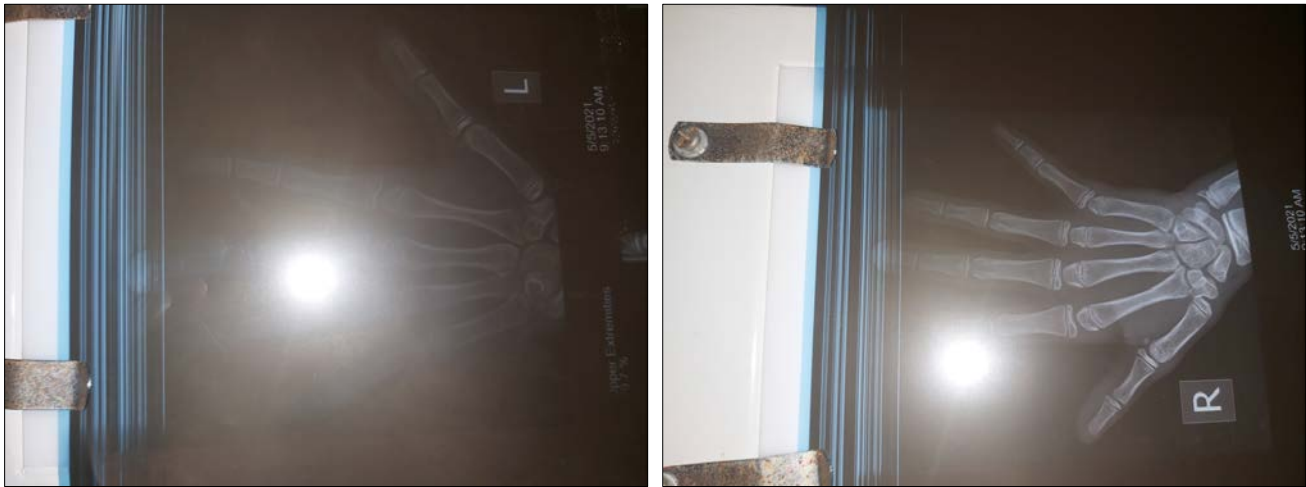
Plain Radiographs of the hands showing normal skeletal pattern/ bony structure
